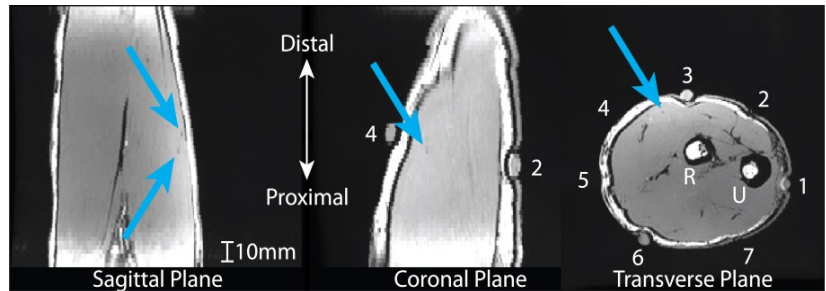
Structural MR images of forearm indicating a hematoma representing the location of a fine-wire electrode within the *extensor carpi radialis brevis* muscle.
